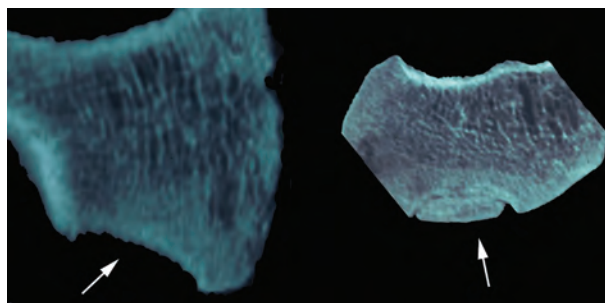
The radiological appearance of the lesions made with computed tomography in horizontal direction on both medial femoral condyles is typical for osteochondritis dissecans. The osteochondral lesions are marked with arrows.*
